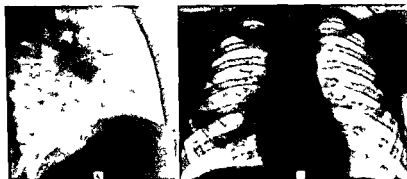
X-rays of a four year old girl showing a shrunken lateral segment of the right middle lobe due to fibrosis caused by epithelioid tuberculosis. A Lateral B Anteroposterior. Note the distinct and sharp border in the interlobar fissures and indistinct border in the intersegmental septum.
